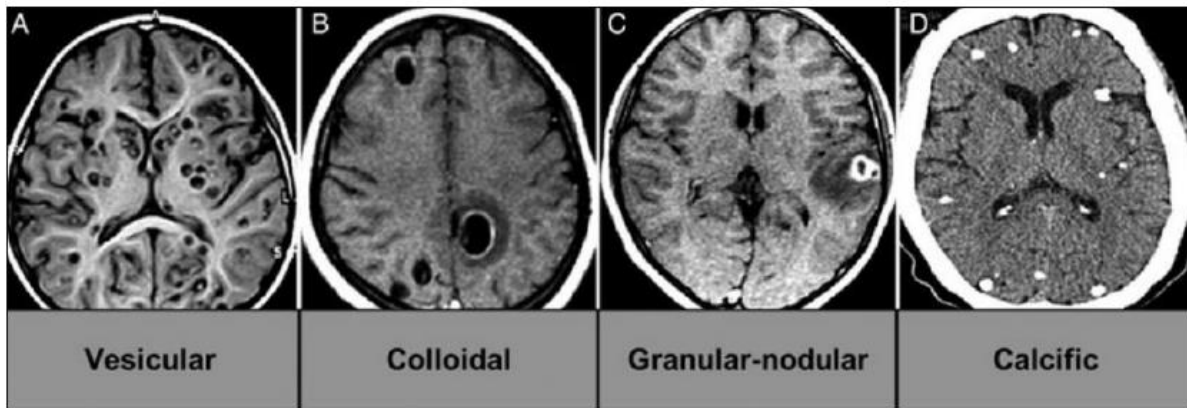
Stages of cysticerci development in parenchymal NCC. An MRI scan of A) vesicular/viable cysticerci, B) colloidal cysticerci, and C) degenerating cysticerci in the granular-nodular stage D) CT scan of calcified cysticerci (Images acquired from Carpio and Romo 2014, and de Lange, Mahanty, and Raimondo 2018).
